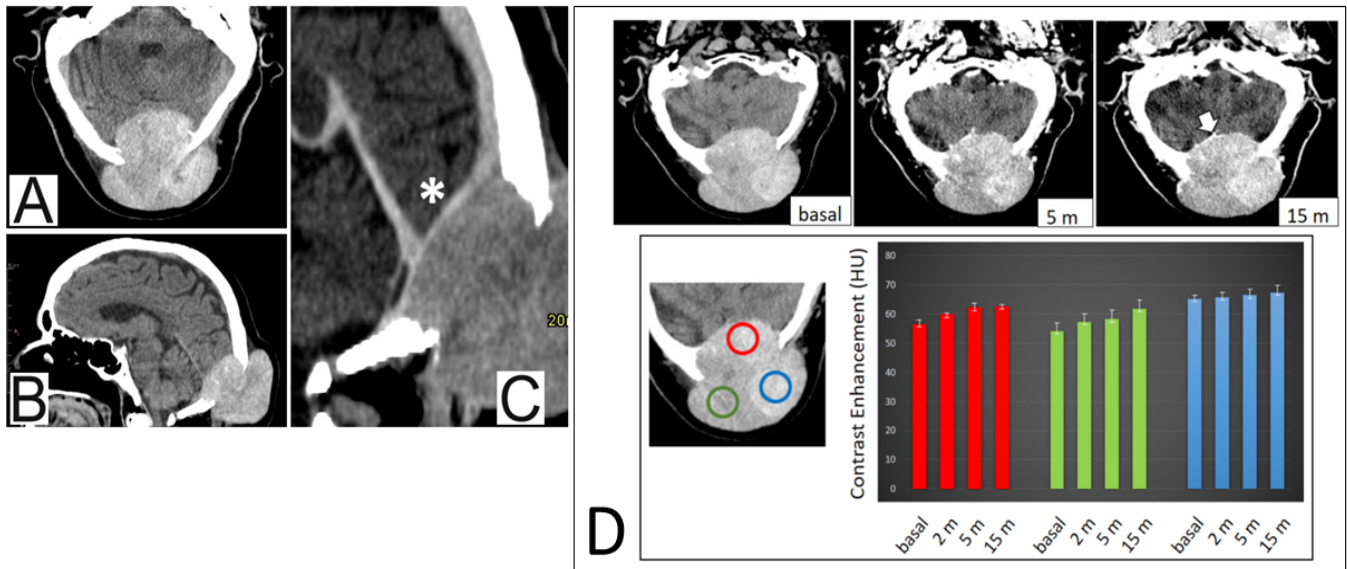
77-year-old woman was referred with a rapidly progressive swelling at the back of the neck. Head computed tomography examination revealed a well-defined, 7 cm heterogeneous occipital mass (56 x 67 x 70 mm), destroying the inner and outer tables of the squamous part of the occipital bone, extending into both the intracranial and extracranial compartments. The brain was normal, and there were no other calvarial lesions. A, B) CT scan, axial and sagittal reconstructions. C) CT scan after iodinated contrast medium injection demonstrating compression of the sagittal sinus and confluence of sinuses (*). GE Revolution EVO 64 CT scanner. D) Contrast Enhancement. CT scan axial sections before (basal) and after (5 minutes; 15 minutes later) iodinated contrast medium injection demonstrate an occipital lytic bone lesion characterized by progressive, heterogeneous fill-in of contrast enhancement, especially in the intracranial region (+10%) and in the right extracranial region (+14%). Graph showing density measurements in three different areas of the mass at baseline and after contrast medium injection (2 minutes, 5 minutes, 15 minutes), as detailed below. There was a subtle rim-enhancement extending along the dural surface (white arrow). Three different areas were randomly selected and marked with three different colors to highlight the heterogeneity of the lesion; the graph shows the quantification in Hounsfield Units (HU) of the three regions of interest (ROIs), before and after iodinated contrast administration at different time points, demonstrating different values across different regions of the lesion. GE Revolution EVO 64 CT scanner.
